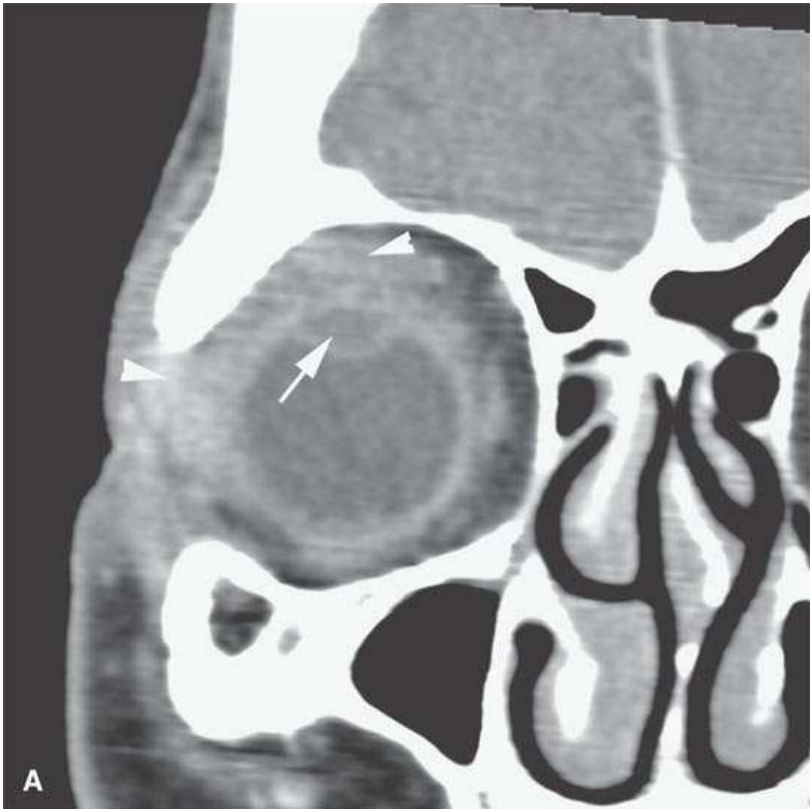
Contrast-enhanced computed tomography of a patient with a particularly unusual pattern of orbital lymphoma (*arrowheads*) with ocular invasion (*arrows*).
